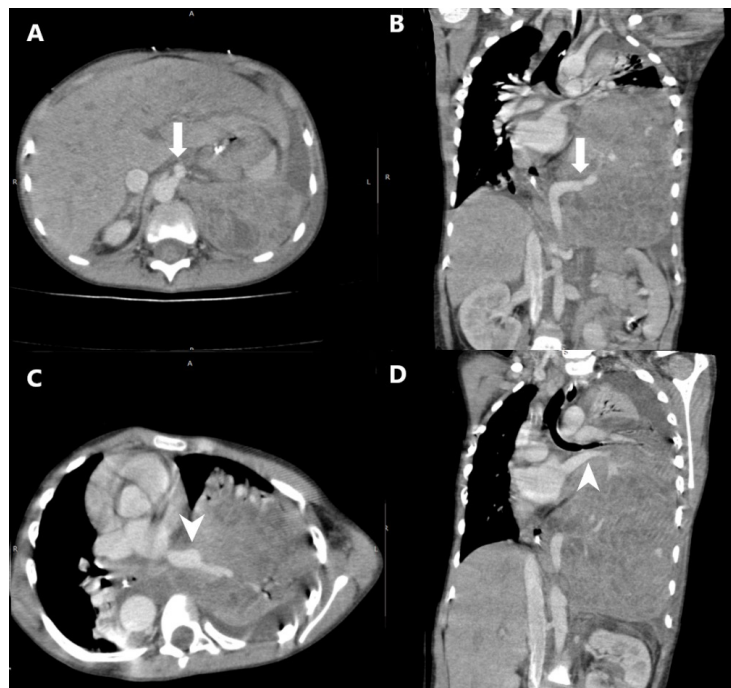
Contrast-enhanced Computed Tomography of the thorax in axial (A and C) and coronal (B and D) view. Multicystic mass at the left hemithorax with arterial blood supply from the aorta (arrow in A and B), while venous return to the pulmonary vein (arrowhead in C and D).
